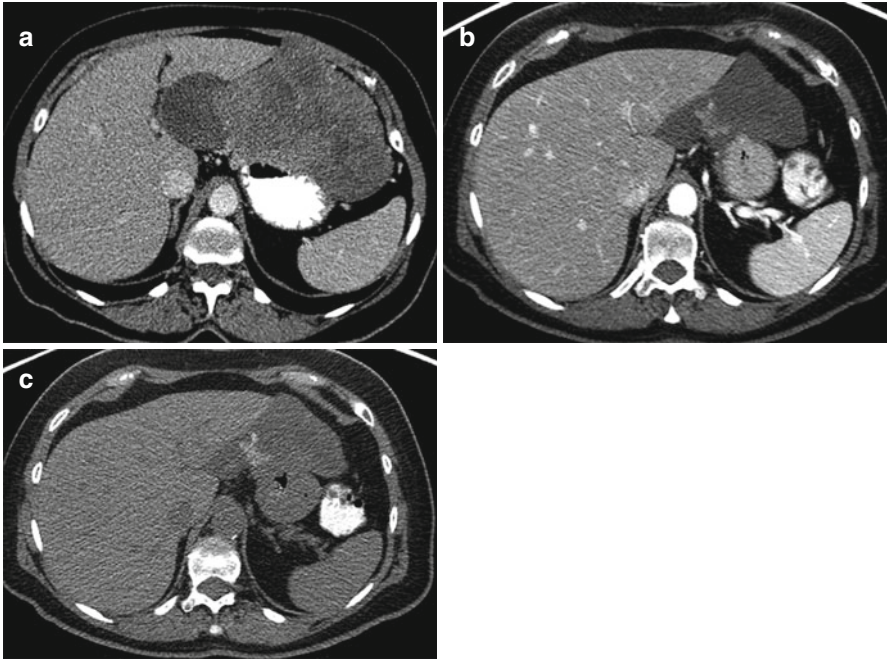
Pseudoprogession with development of intratumoral calcification in a 66-year-old woman with gastric GIST. (a) The pretreatment CT shows an exophytic gastric GIST. (b, c) At 12 months after treatment, the tumor has responded well, with a significant decrease in size and tumor attenuation. Note that the intratumoral hyperattenuating nodular densities (b) are calcifications without enhancement, confirmed on unenhanced imaging (c)
